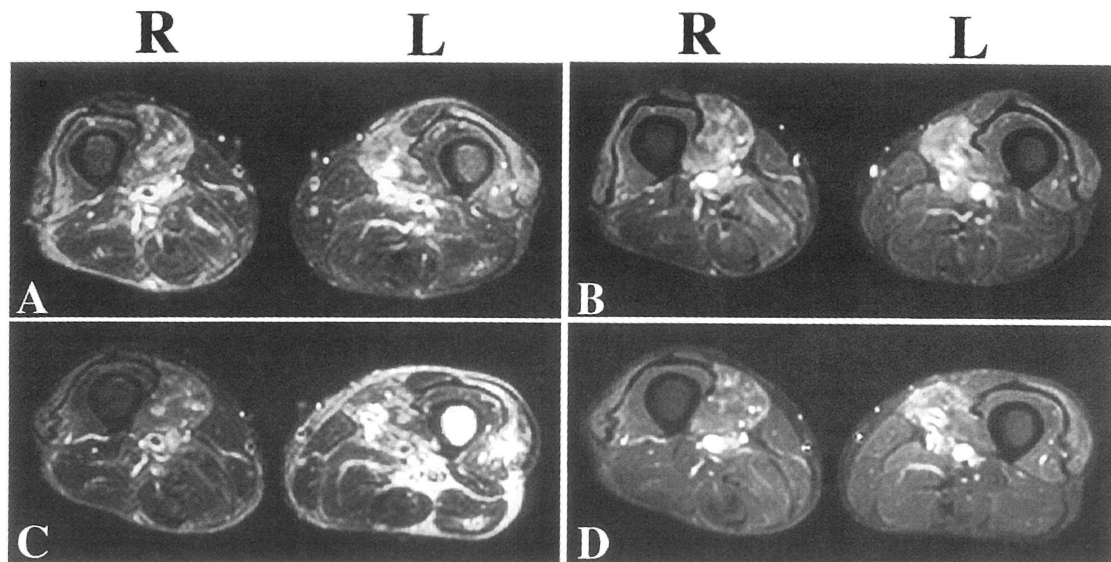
MRI of the thigh muscles in case 1. High signal lesions of the quadriceps on a T2-weighted image (TR 2600, TE 102) (A) and the gadolinium enhancement on a T1-weighted image (TR 533, TE 11) (B) are reduced markedly on the right side and mildly on the left side after the treatment (C, D).
